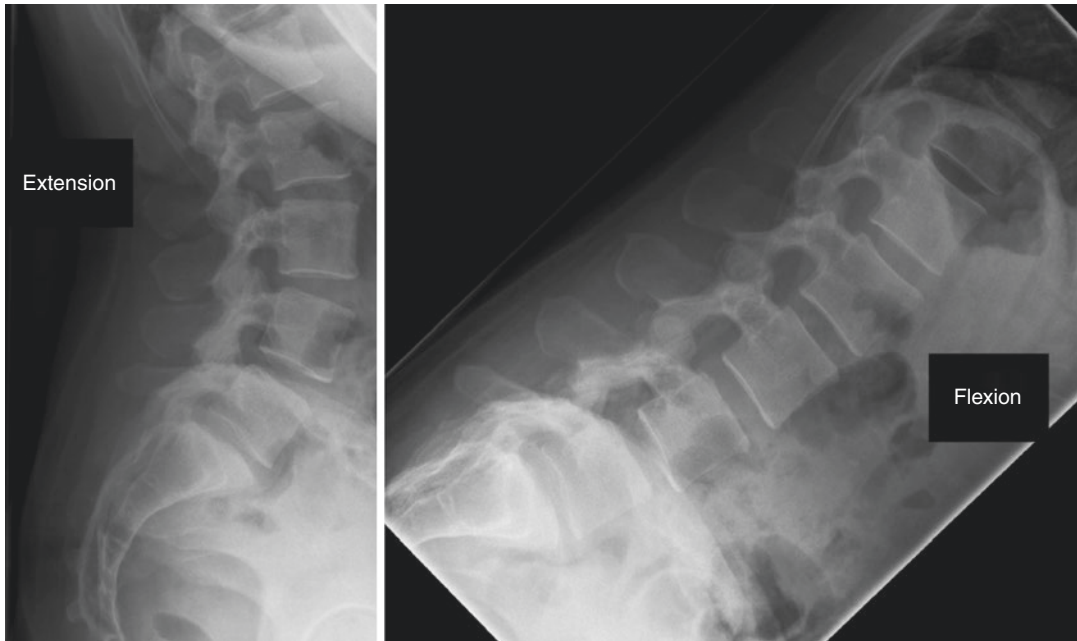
Dynamic radiographs (Flexion/Extension) of the lumbar spine. No signs are apparent instability are noted
